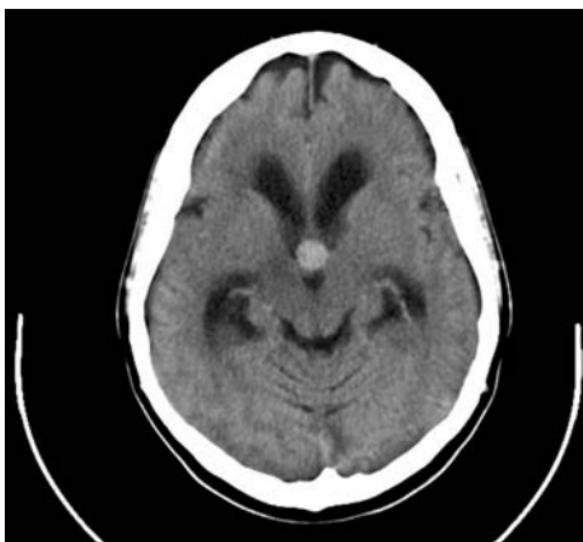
Third ventricular colloid cyst (non-enhanced CT). Rounded hyperdense lesion in the anterior aspect of the third ventricle at the site of the foramen of Munro causing subsequent obstructive hydrocephalus with dilatation of the lateral ventricles.
